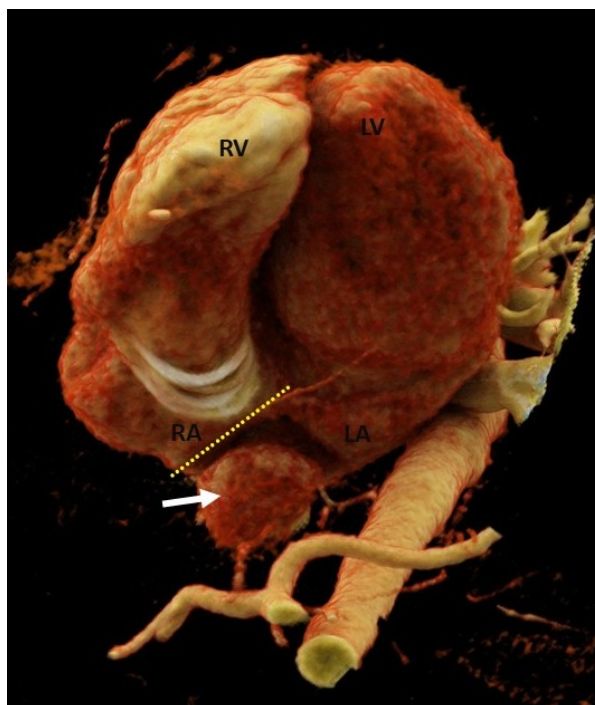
CT Angiography Cinematic VRT (Volume Rendering Technique) reconstruction demonstrating the relationship between the surgical patch (yellow dotted line) and the redirected IVC pathway (white arrow) into the left atrium. (abbreviation: RA- right atrium, LA- left atrium, RV- right ventricle, LV- left ventricle).
